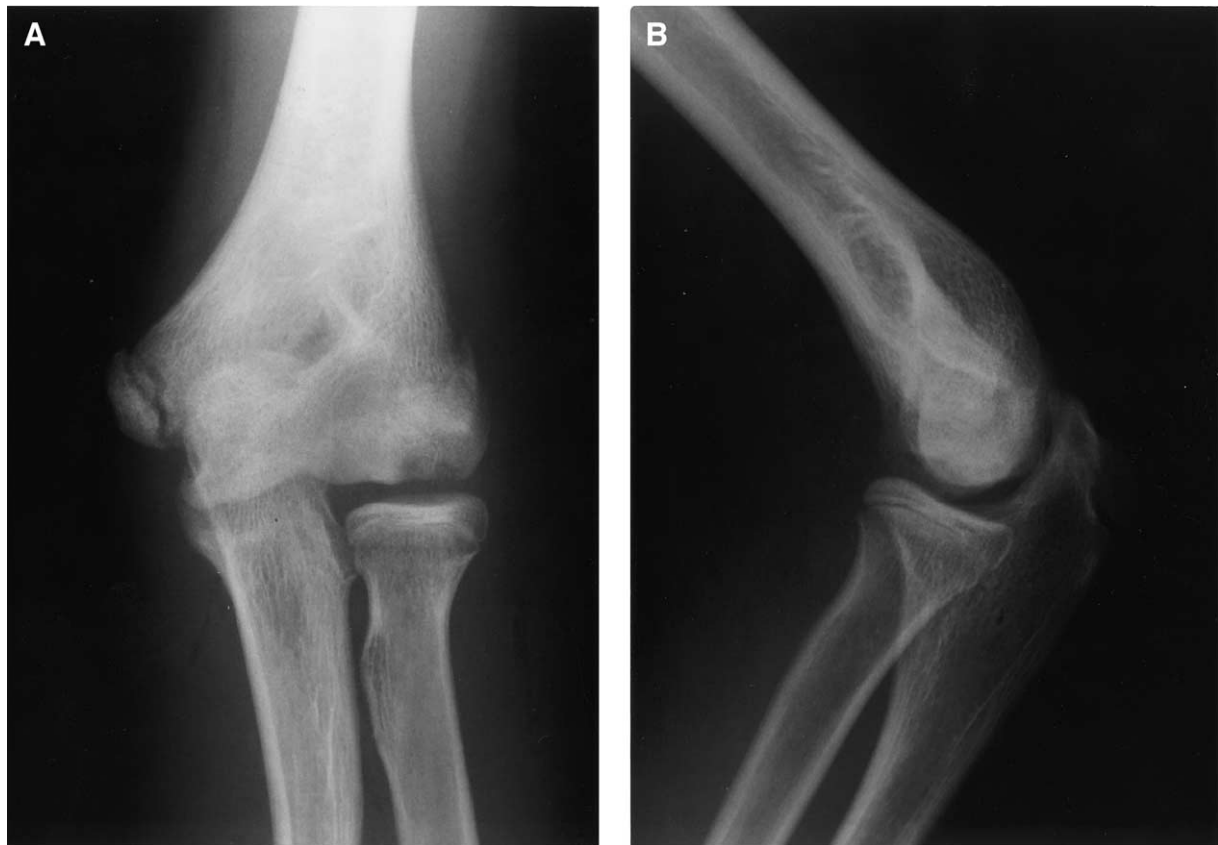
A, An anteroposterior radiograph taken with the elbow in 45° of flexion clearly shows the lesion. B, Lateral radiograph of elbow joint.
